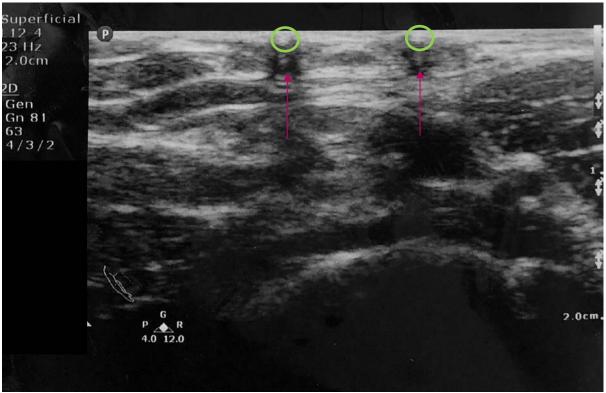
Ultrasound of two Jadelle implants in transverse scanning
